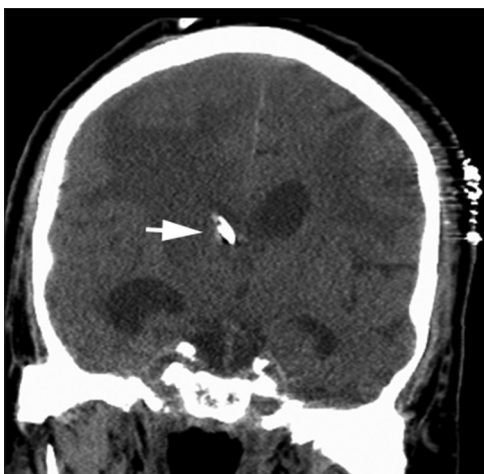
Computed tomography of head without contrast coronal view shows location of the catheter tip within the ventricle, denoted by the arrow
